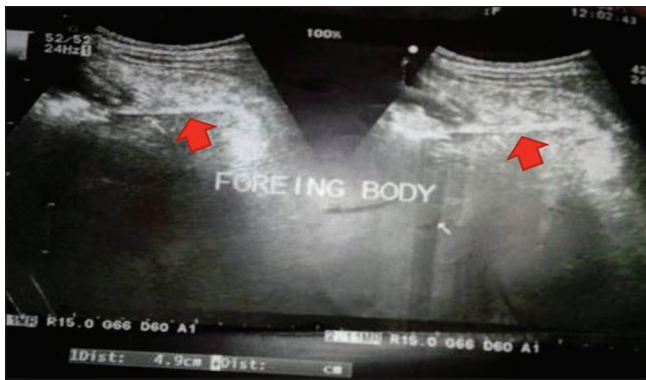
Ultrasonography upper abdomen - red arrows showing datun (wooden chewing stick) in stomach
